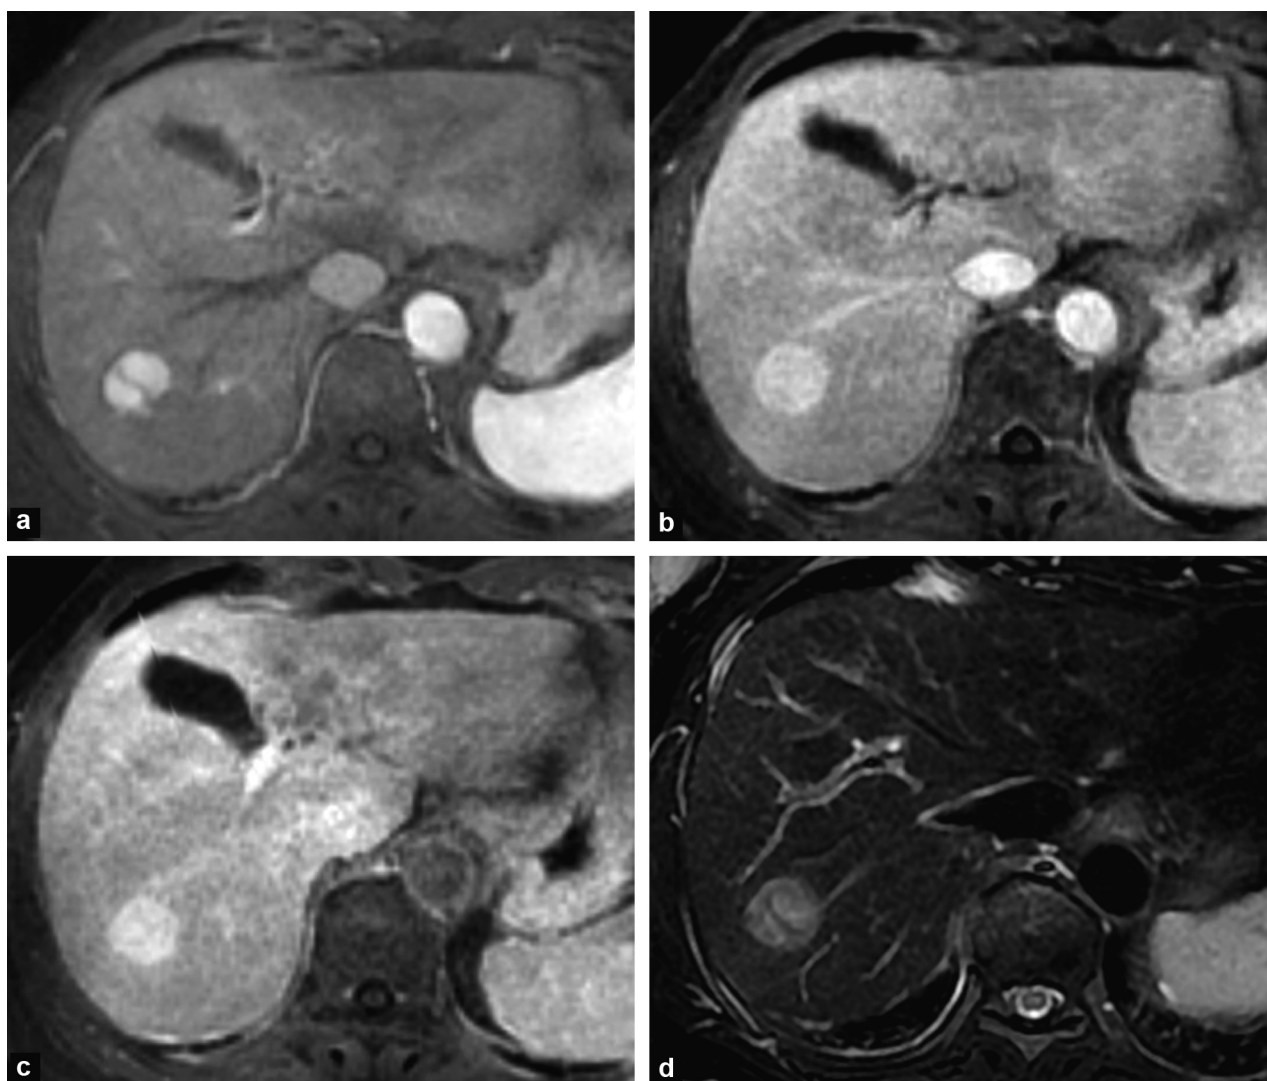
The usefulness of T2-weighting. Monitoring examination for cirrhosis of exogenous origin. T1-weighted MRI with fat saturation after gadolinium injection in the arterial (a), portal (b) and late (c) phases, and with T2-weighting (d): hepatocellular carcinoma enhanced in the arterial phase after injection, without washout of the lesion in the portal and late phases, but with hyperintensity with T2-weighting.
